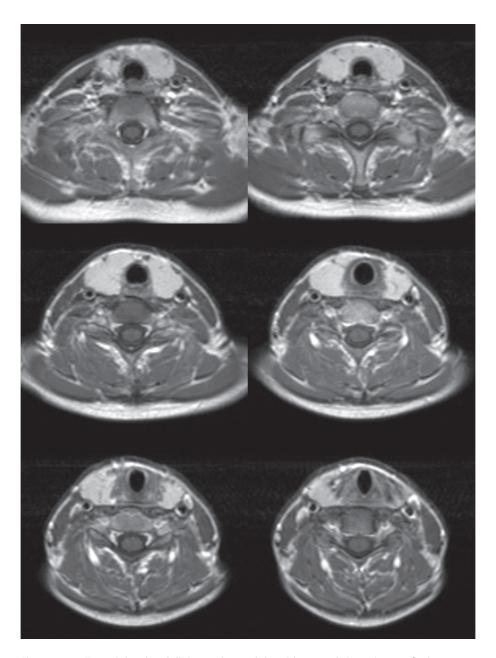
T1-weighted gadolinium enhanced thyroid MRI study in patient #6 (only 6 cross-sections shown).
